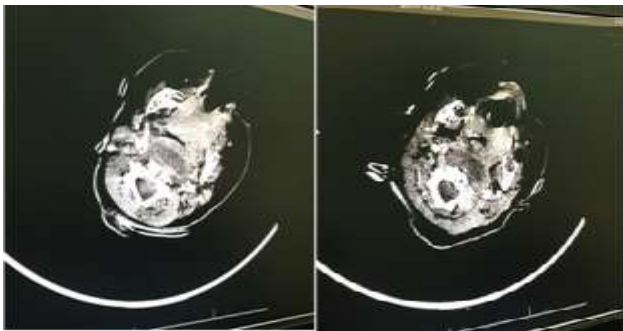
CT scan showing hypodense retropharyngeal collection.
